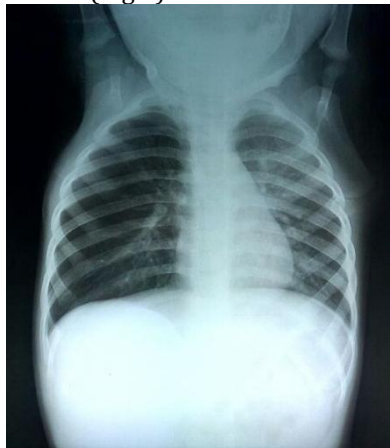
Chest x-ray during admission
